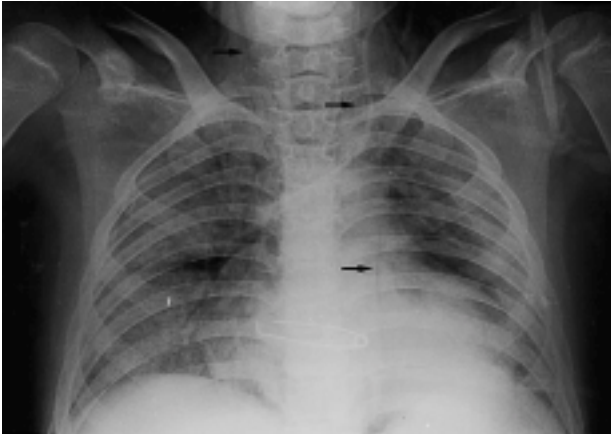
Anteroposterior chest radiograph revealing fine streaks of air (arrows) within mediastinum, extending upwards to the neck.
